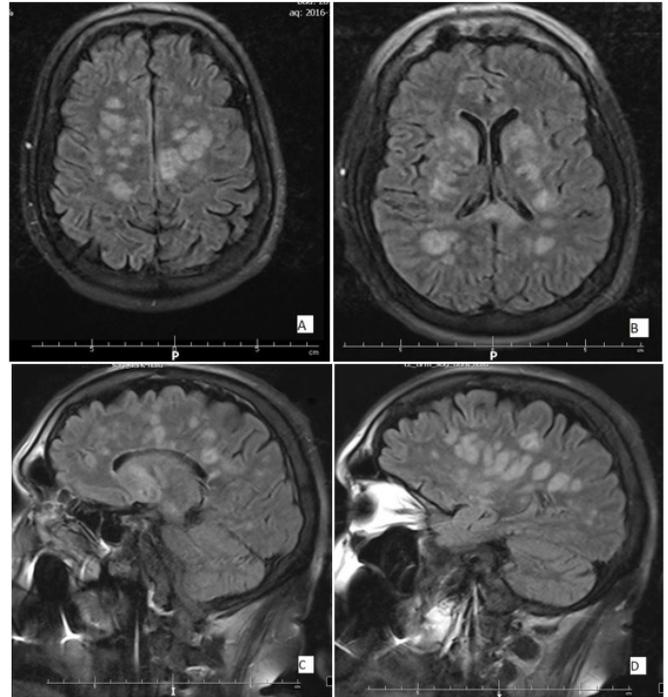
MRI of the CNS performed on the 8th of November 2016 - at the time of diagnosis of candidiasis with CNS involvement (T2-weighted images).
